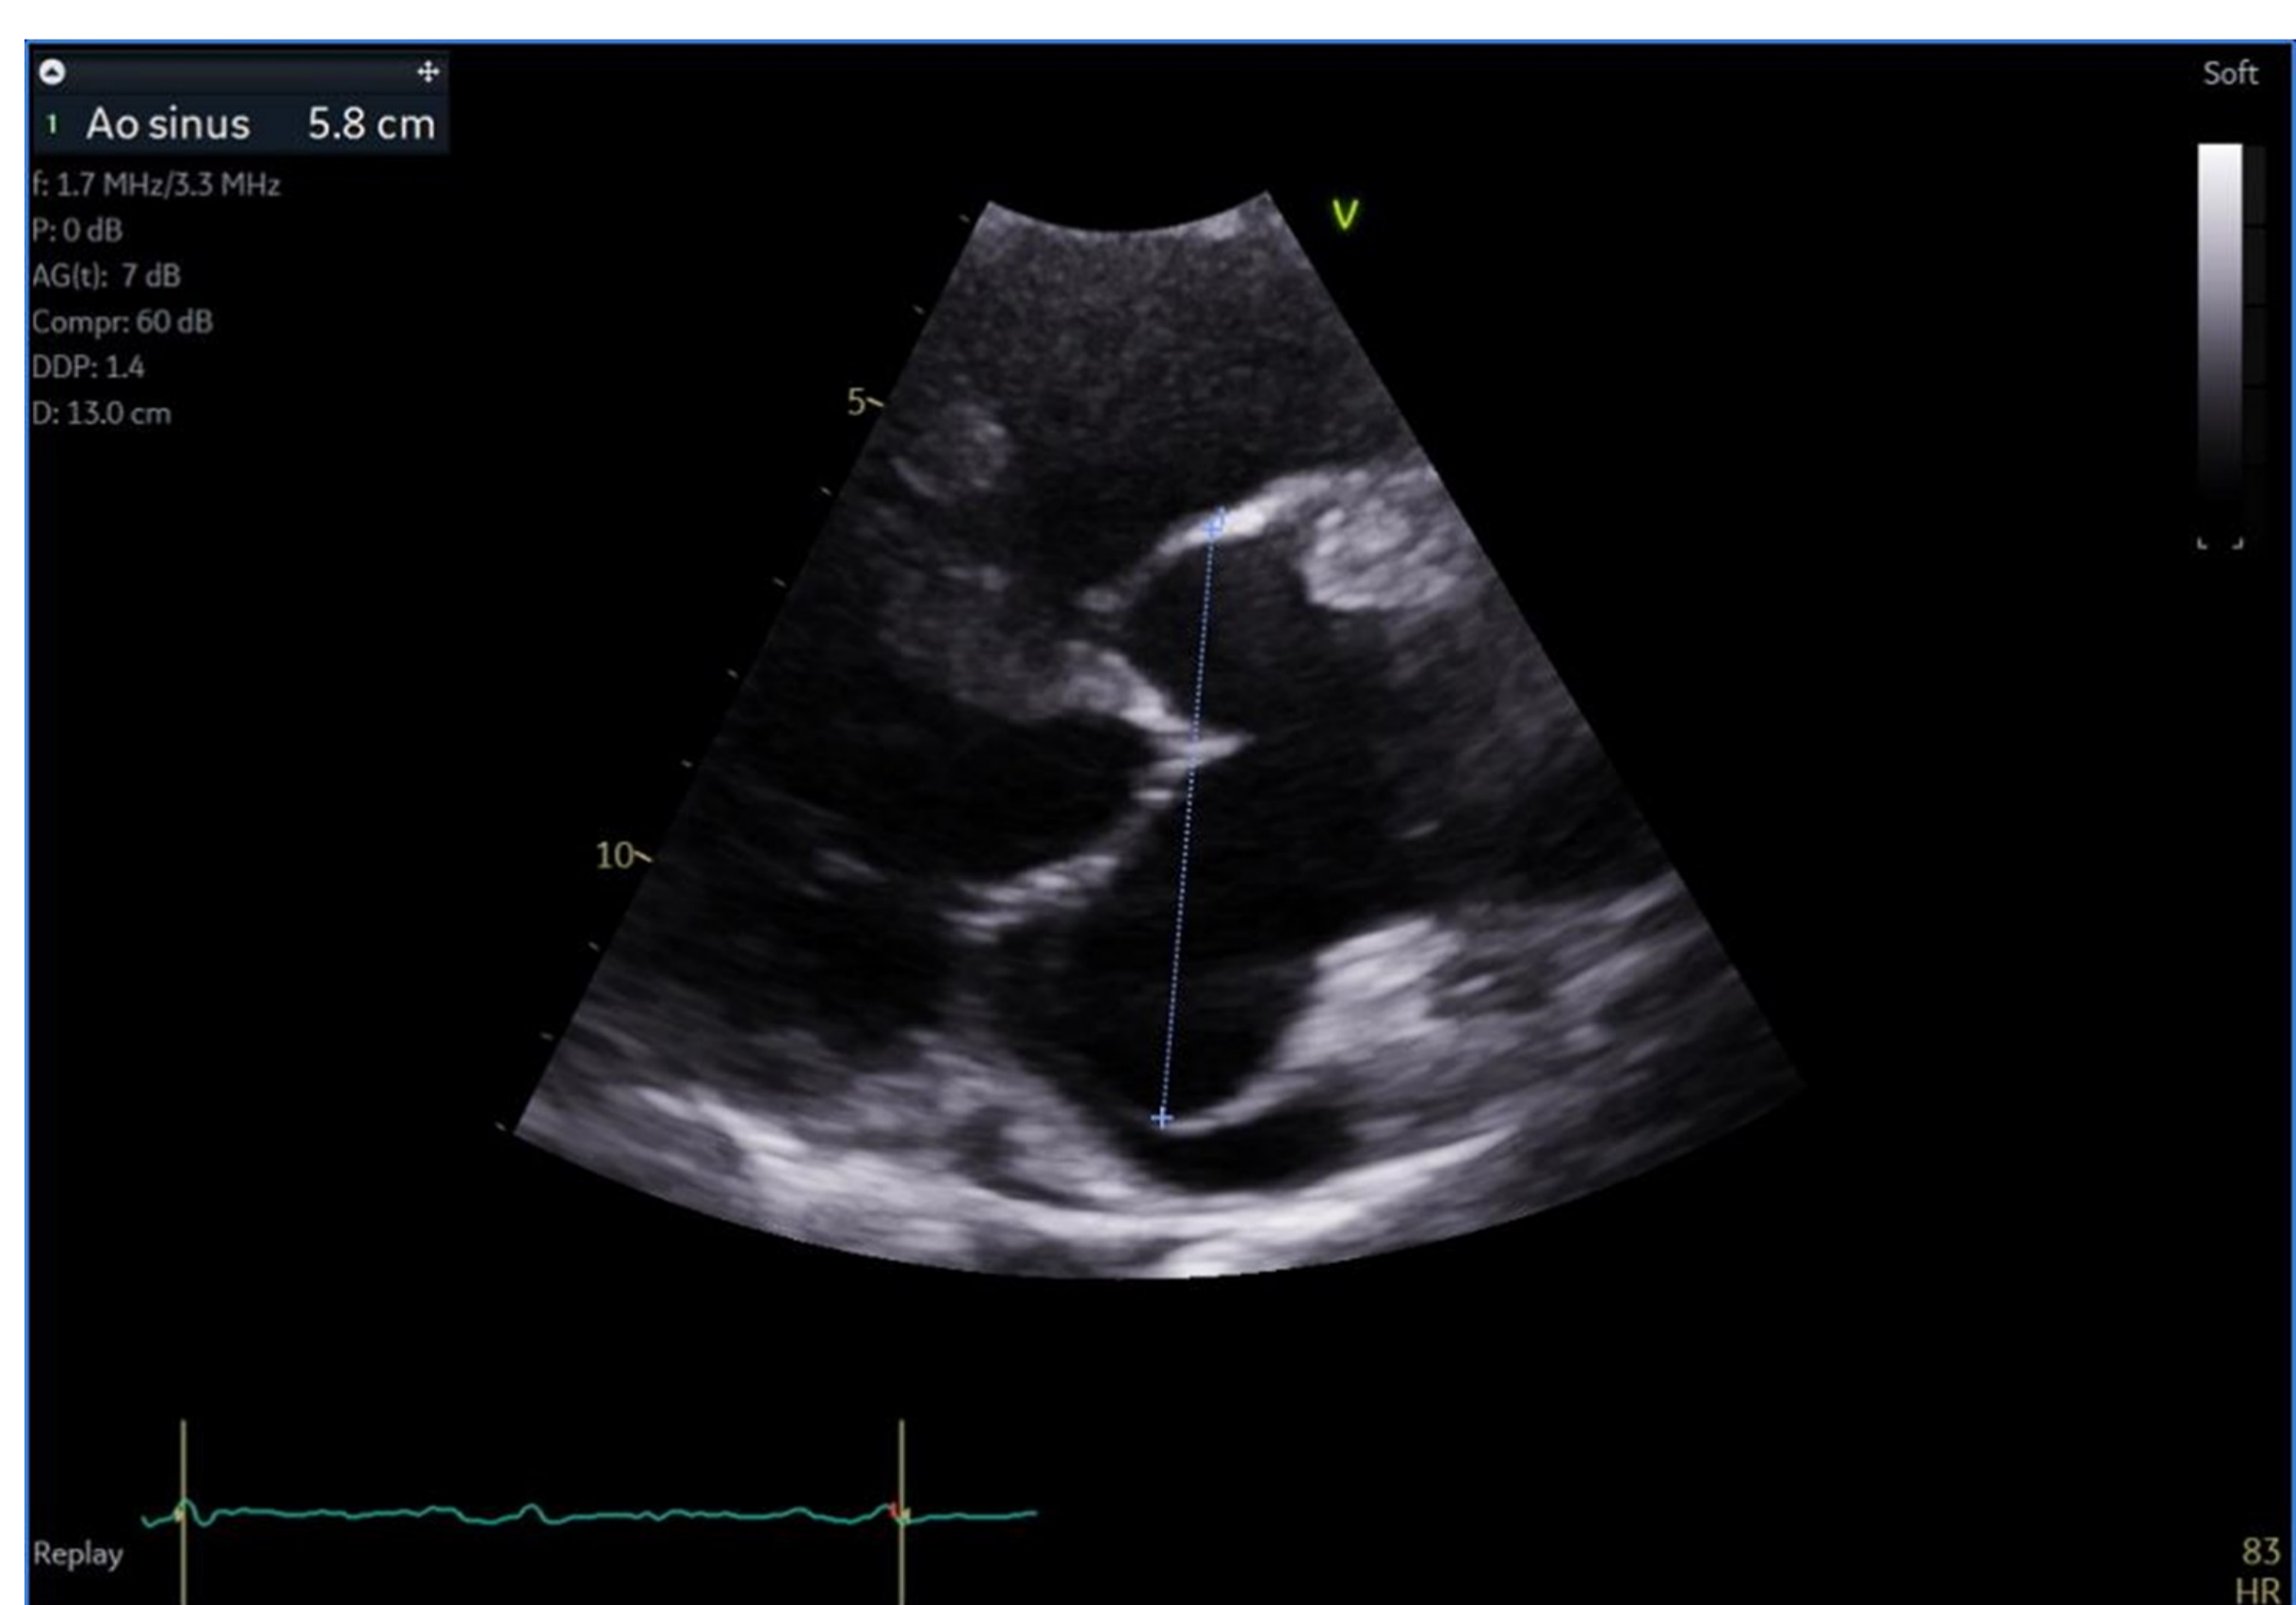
Parasternal short Axis showing SOVA affecting the non-coronary sinus
